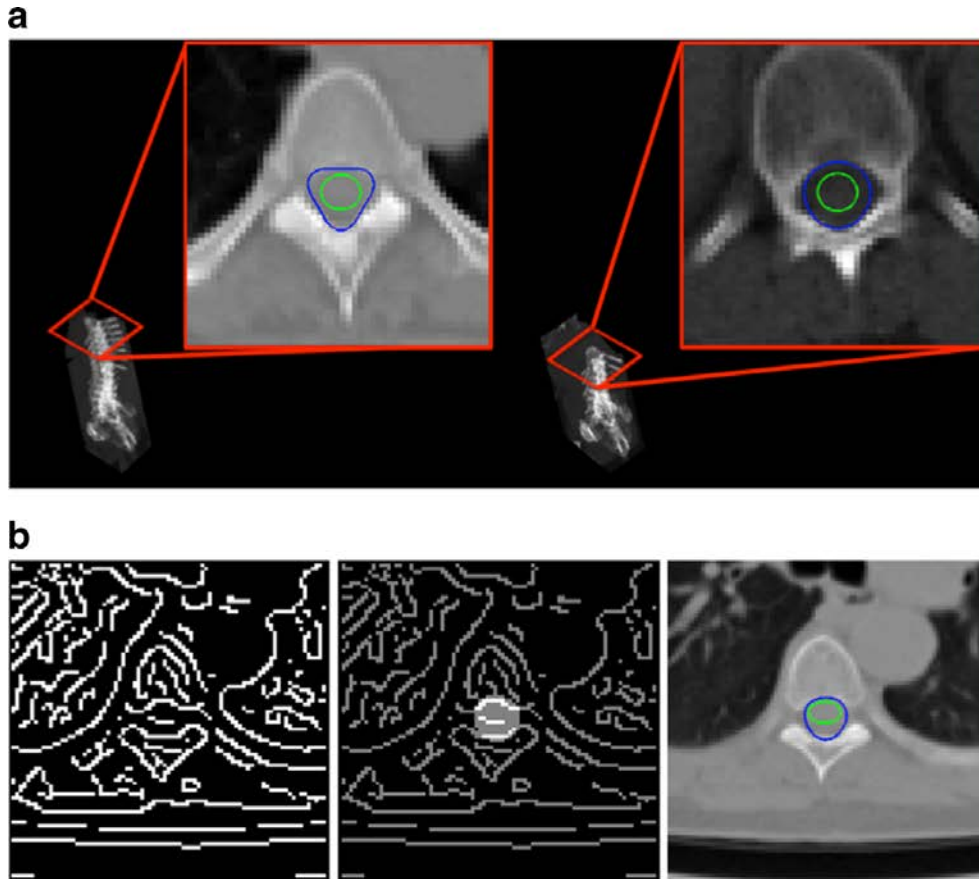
(a) Detection of spinal canal and spinal cord at different heights of the vertebral column. The Hough transform-based procedure with respect to the curve with three convexities allows identification of the spinal canal (*blue line*), while the spinal cord is detected by the Hough transform-based procedure with respect to the ellipse (*green line*). (b) *Left to right*: edge detection of a CT slice in the vertebral region; edge points inside the region bounded by the curve with three convexities (*blue line*) and the ellipse (*green line*) detected by applying the Hough transform-based procedure.
